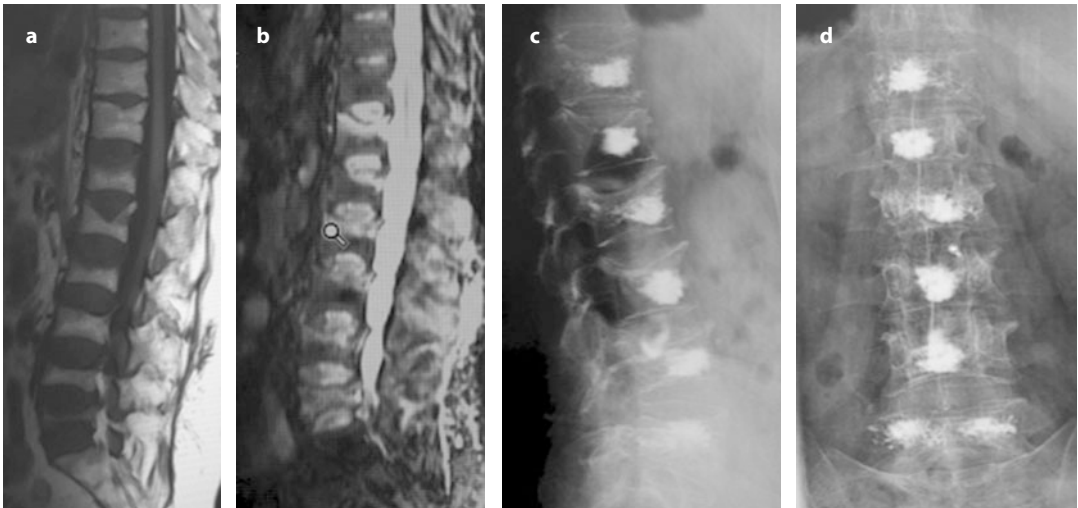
65-year-old female with severe osteoporosis due to long-term corticosteroid therapy. Sagittal T1-weighted MRI shows multiple vertebral fractures from T12 to L5 with hypointense signals (a). All vertebral bodies from T12 to L5 show hyperintense signals on T2-STIR MRI due to bone-marrow edema (b). Left lateral and anteroposterior views under fluoroscopic control after one session of multilevel VP with a unipedicular approach from T12 to L5 show good distribution of cement (Cerament™) without venous or disk leakage (c and d)
